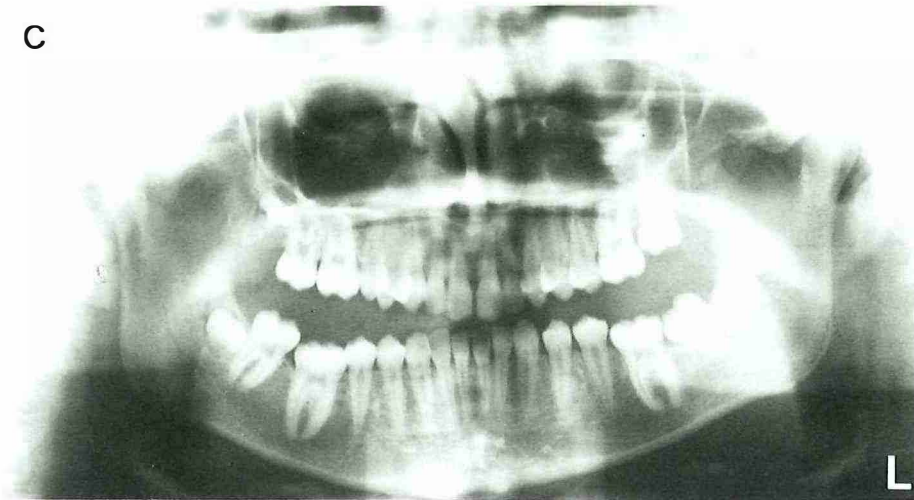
C Orthopantomogram of the same patient after 4 year showing secondary retention of the mandibular right and left first permanent molar.
